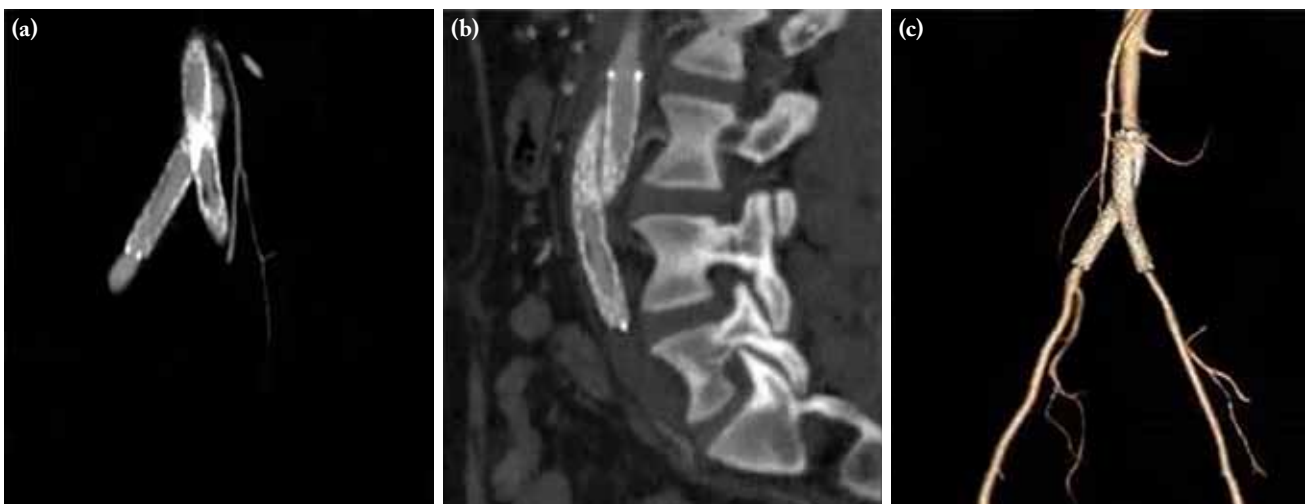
Computed tomography angiography (a-c) six months after intervention showing no significant interval change in the residual stenosis on the left side. No aortoiliac or femoral aneurysm appeared.
